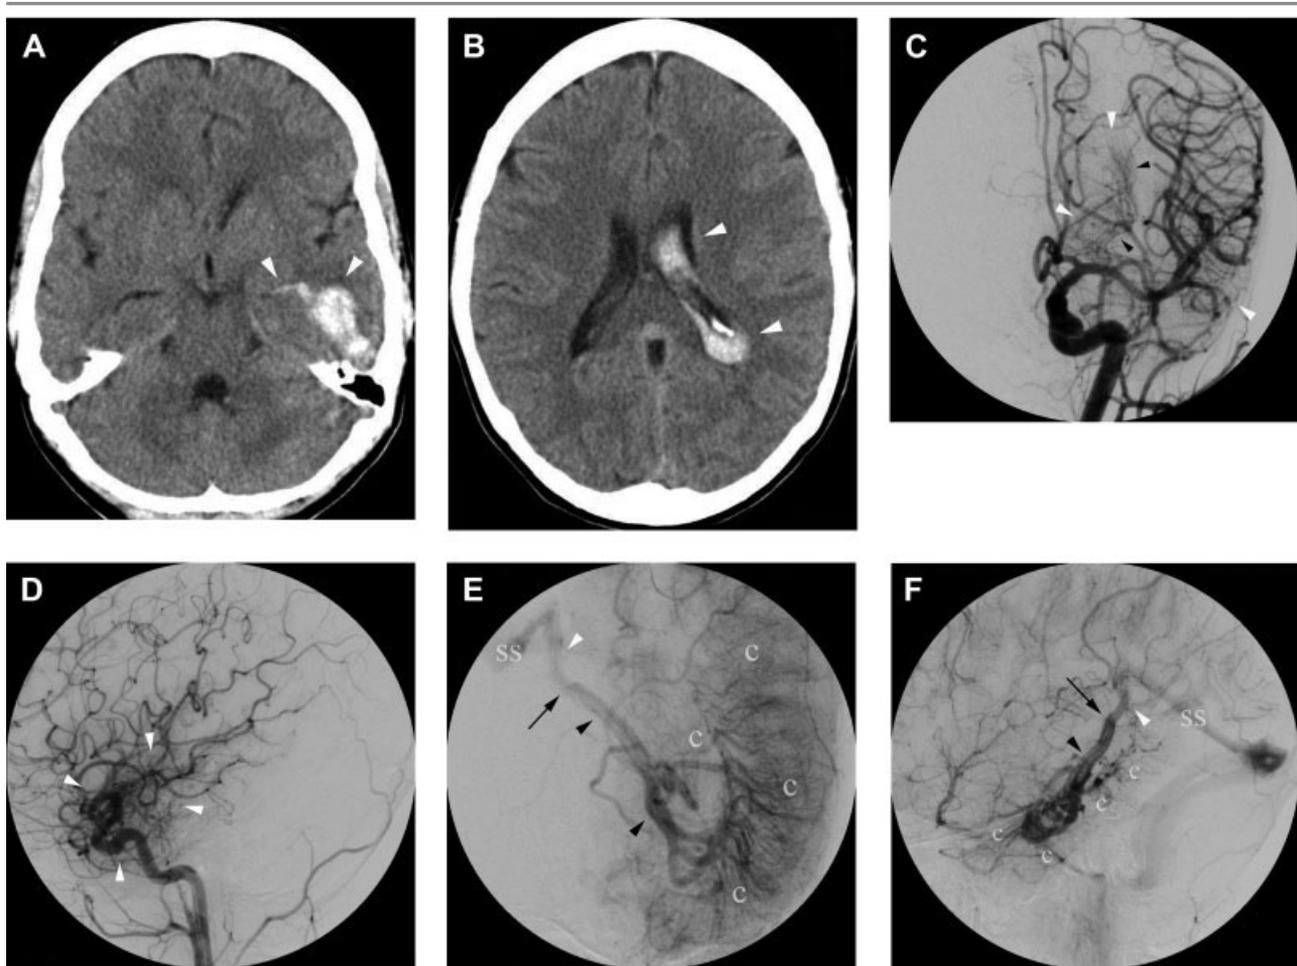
A 32-year-old woman presenting with left temporoparietal headaches and word-finding difficulties. Noncontrast CT disclosed a left temporal lobe and left lateral ventricle hemorrhage. MRI demonstrated a patent complex left temporal lobar DVA draining into the basal vein of Rosenthal. Because of the hemorrhagic presentation, DSA was performed, revealing a Type 2 arterialized DVA. (A) Noncontrast CT showing an intraparenchymal hemorrhage of the left temporal lobe (arrowheads) extending into the temporal horn of the lateral ventricle; (B) hemorrhage in the left lateral ventricle; (C–F) DSA, left internal carotid artery injection, anterior-posterior (AP) (C) and lateral projections (D) of the mid-arterial phase showing slightly enlarged lateral lenticulostriate arteries (black arrowheads) and a vascular blush (white arrowheads). There is no evidence of an AVM nidus, but the enlarged lenticulostriate arteries are consistent with a Type 2 arterialized DVA; (E, F) same injection and projection as (C, D), venous phase. The large complex DVA of the left temporal lobe is now clearly visible. Note the slight stenosis (black arrow) at the junction of the collecting vein (black arrowhead), in this case the basal vein of Rosenthal, and the great vein of Galen (white arrowhead). *c* = caput medusae; *SS* = straight sinus.
